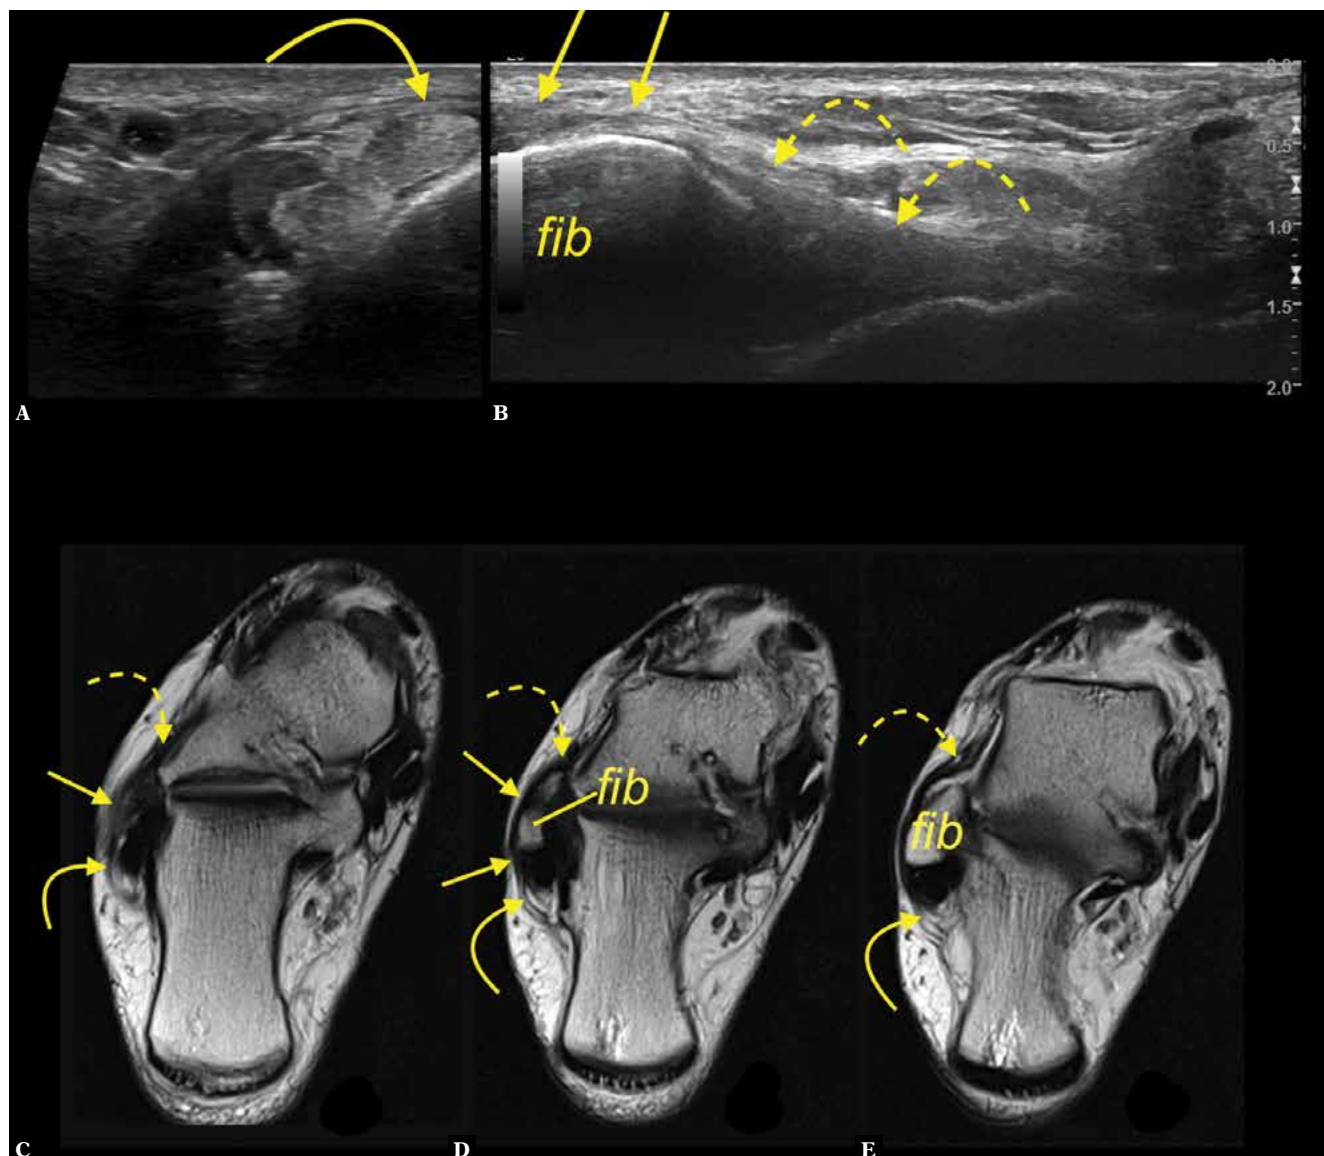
A 34-year-old patient with a suspicion of a ganglion. A, B. transverse section on ultrasound corresponding to section d. C, D, E. T2-weighted slightly oblique section. The interconnection (straight arrows) between the SPR (curved arrow) and ATFL (curved dashed arrow); fib – fibula
